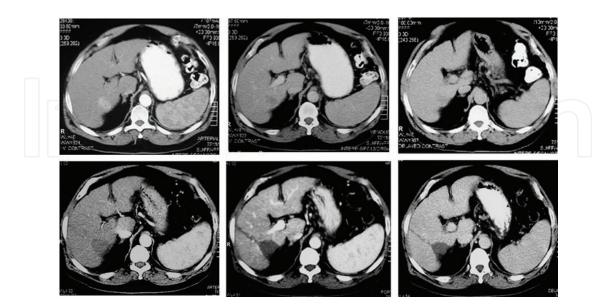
Above, left to right: Triphasic CT scan revealed enhancing right lobe focal lesion (segment VII) showing washout in the portovenous phase and in the delayed phase. Below, left to right: Post-RFA triphasic CT scan obtained 1 month later revealed complete necrosis with no residual enhancing tumor.
